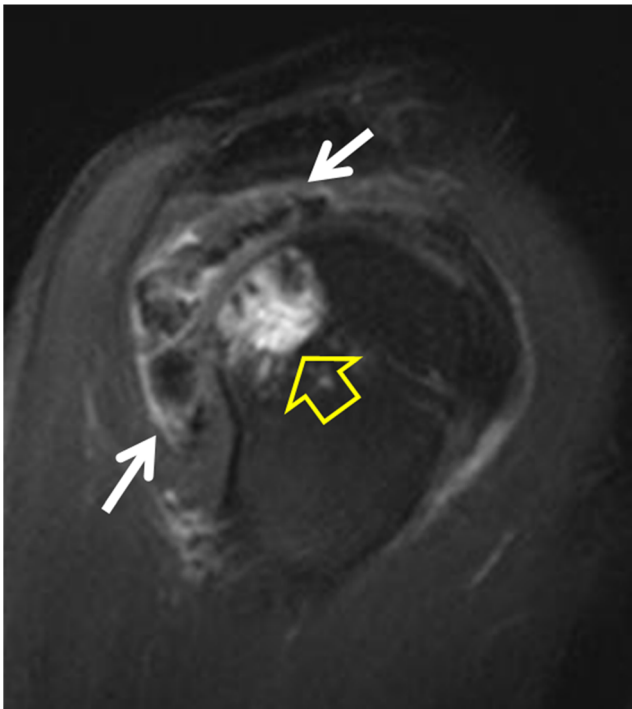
Same patient as in Fig. 2. The fat-suppressed oblique sagittal T2-weighted MRI shows extensive calcifications within the subdeltoid bursa (*arrows*) and the subcortical bone marrow change with small foci of calcifications (*open arrow*)
